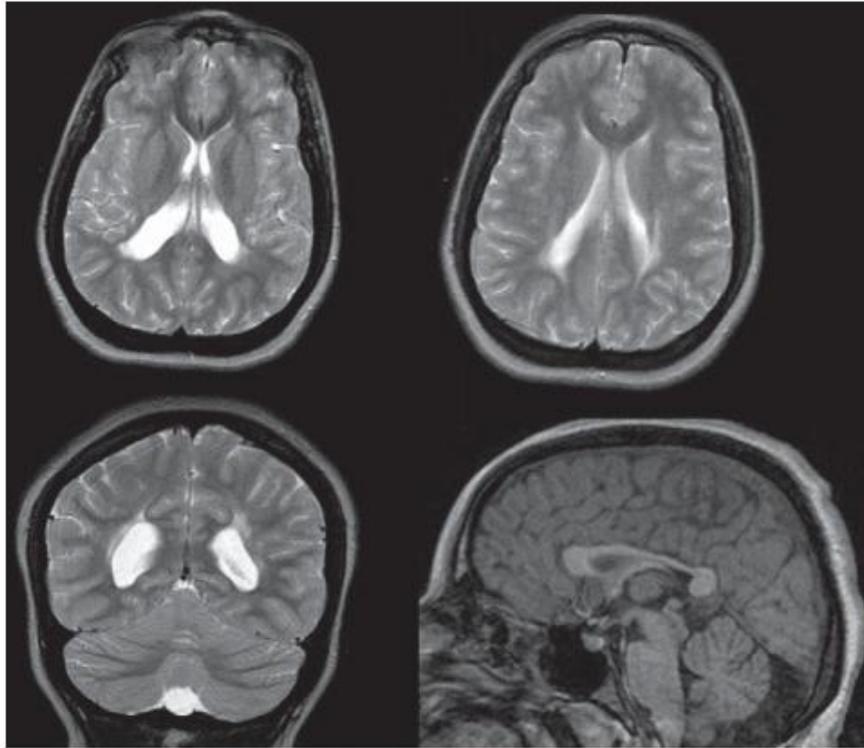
End-stage changes of periventricular leukomalacia. A child with spastic diplegia scanned much later in life (15 years) has the typical chronic changes of periventricular leukomalacia. There is posterior periventricular increased signal on T2-weighted images and enlargement of the ventricles posteriorly with irregular, scalloped margins, indicating white matter loss. The corpus callosum seen on the sagittal T1-weighted MRI is markedly thinned, particularly affecting the posterior body.
